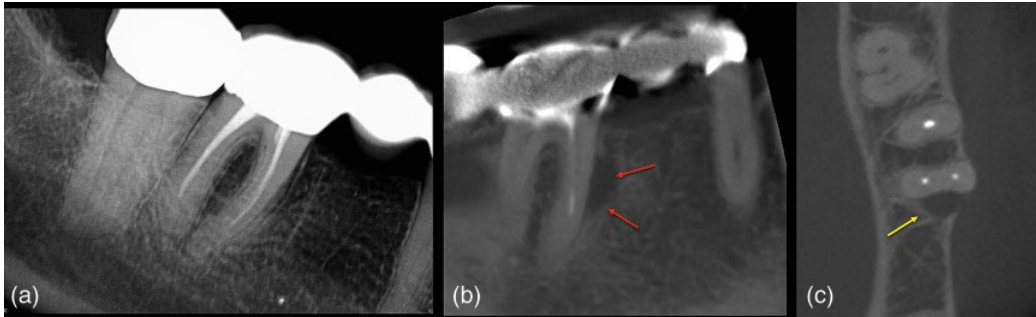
Vertical root fracture. (a) A periapical radiograph of the lower right molar teeth does not reveal anything untoward, however, the (b) sagittal (red arrows) and (c) axial (yellow arrow) CBCT slices reveal a clear radiolucency associated with the mesial root.
